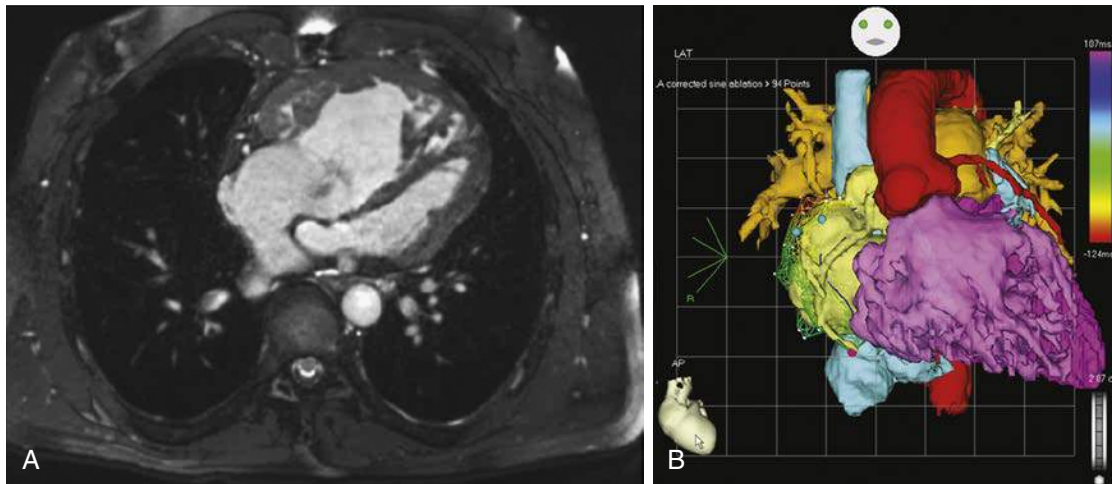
A, Noncontrast three-dimensional (3D) cardiac magnetic resonance imaging of a patient with transposition of the great arteries and atrial switch operation (Mustard). B, 3D reconstruction of the same image data to allow detailed procedure planning (Polaris, Biosense Webster).
